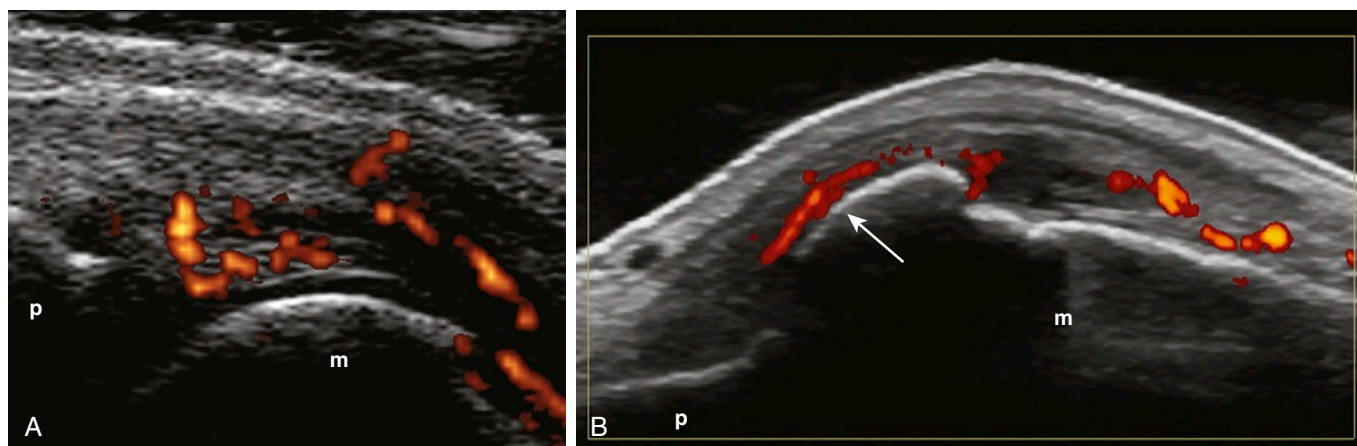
RHEUMATOID ARTHRITIS OF THE HAND. Longitudinal dorsal scans were obtained at the metacarpophalangeal joint level. A, Early disease. With the use of power Doppler technique, active pannus is seen very close to the hyaline cartilage, and there are no signs of cartilage damage. B, Advanced disease. Hyaline cartilage of the metacarpal head has been completely reabsorbed, and the inflamed pannus is attached to the subchondral bone (*arrow*). m, metacarpal bone; p, proximal phalanx.
